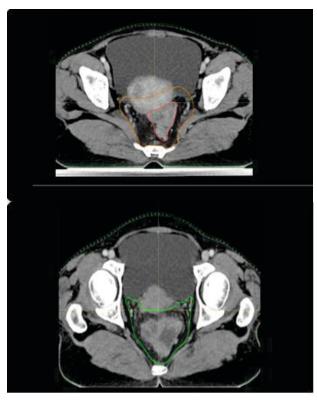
Images showing Radiation planning on CT-Sim for locally advanced rectal carcinoma
